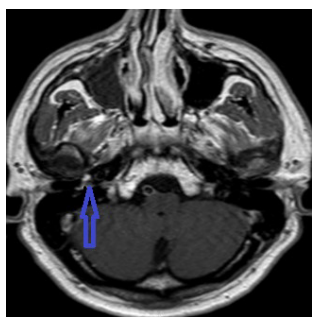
c. Before treatment T1 postcontrast axial MRI scan (thin blue arrow)
